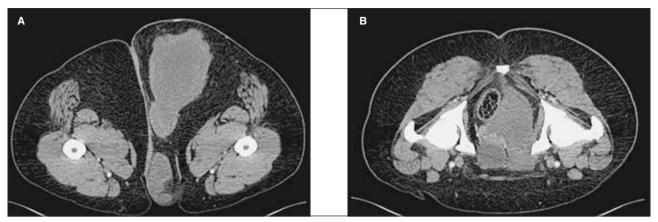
1A. CT scan showing intra- and extra-pelvic mass. 1B. CT scan showing locoregional recurrence.
